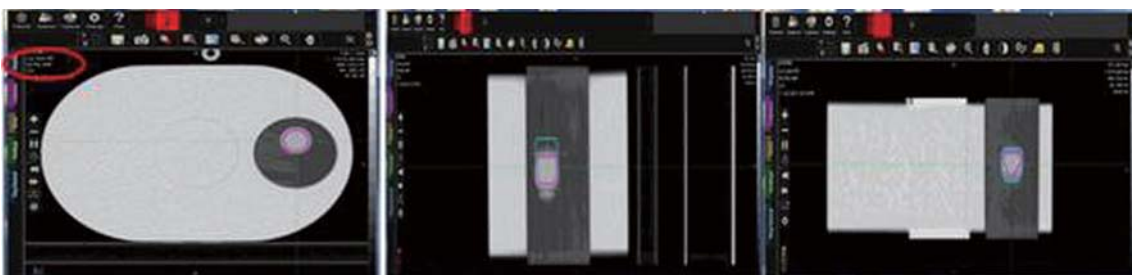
A typical series of CT images in transverse, sagittal, coronal view by amplitude-binning algorithm
